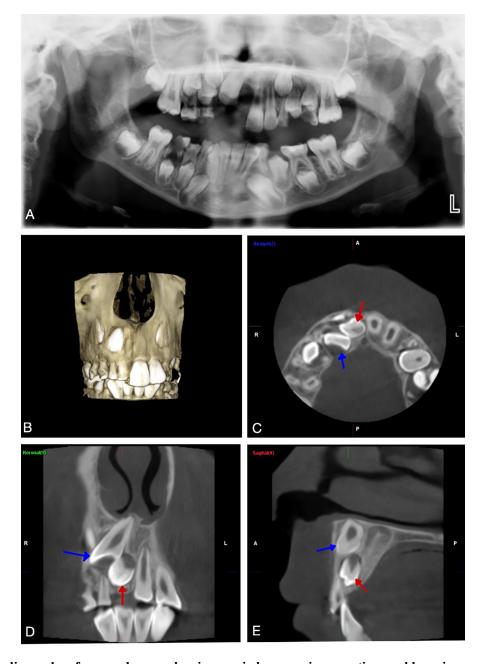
Radiographs of a sample case showing mesiodens causing eruption problems in permanent teeth. (A) Panoramic radiographic image. The position of the mesiodens could not be clearly observed. (B) 3D reconstruction image. (C) Axial CBCT image. Mesiodens was observed to the right of the midline. (D) Coronal CBCT image. (E) Sagittal CBCT image (blue arrows pointed to tooth #11, red arrows pointed to mesiodens).
